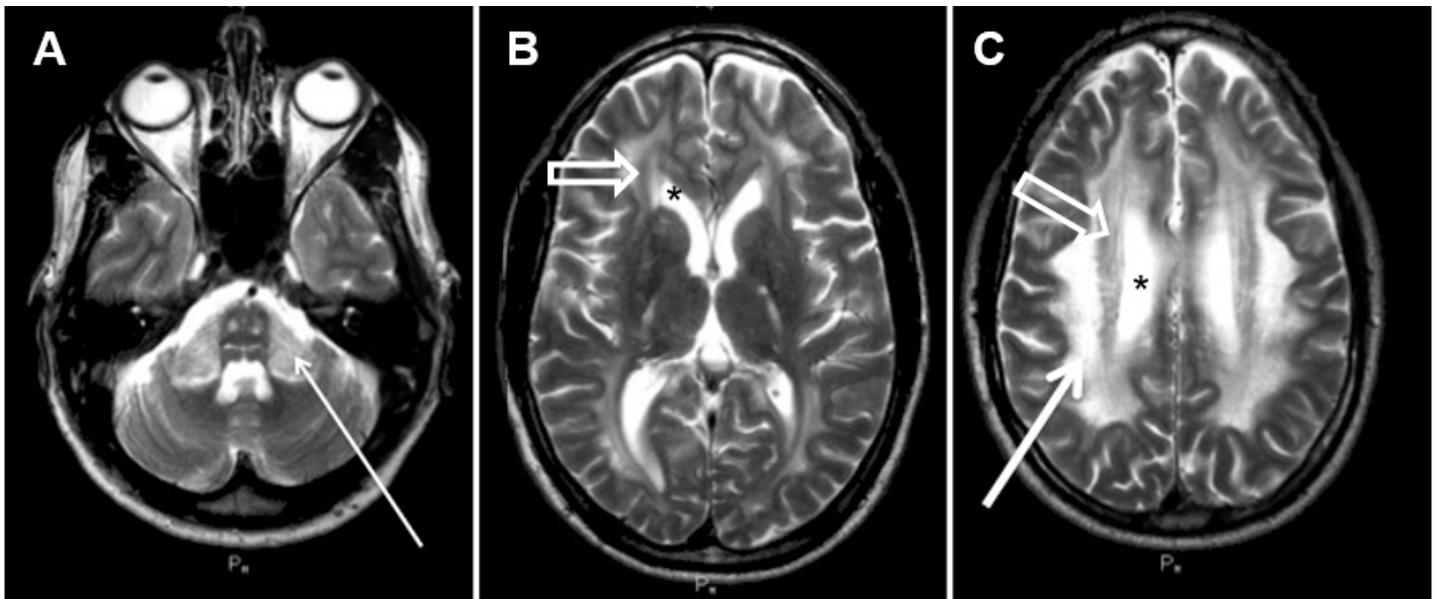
T₂-weighted spin echo MR images from a male age 55 years with *LMNB1*-related ADLD with autonomic symptoms. Axial slices at the levels of the pons (A), the III ventricle (B) and the upper lateral ventricles (C). The middle cerebellar peduncles are involved (A, thin arrow). Corticospinal tract involvement is seen as hyperintensities both in the pons (A) and in the posterior limbs of the internal capsules (B). Extensive supratentorial white matter changes are seen in B and C (thick arrow). Less affected periventricular rims (B and C, open arrows) are characteristic for *LMNB1*-related ADLD.
